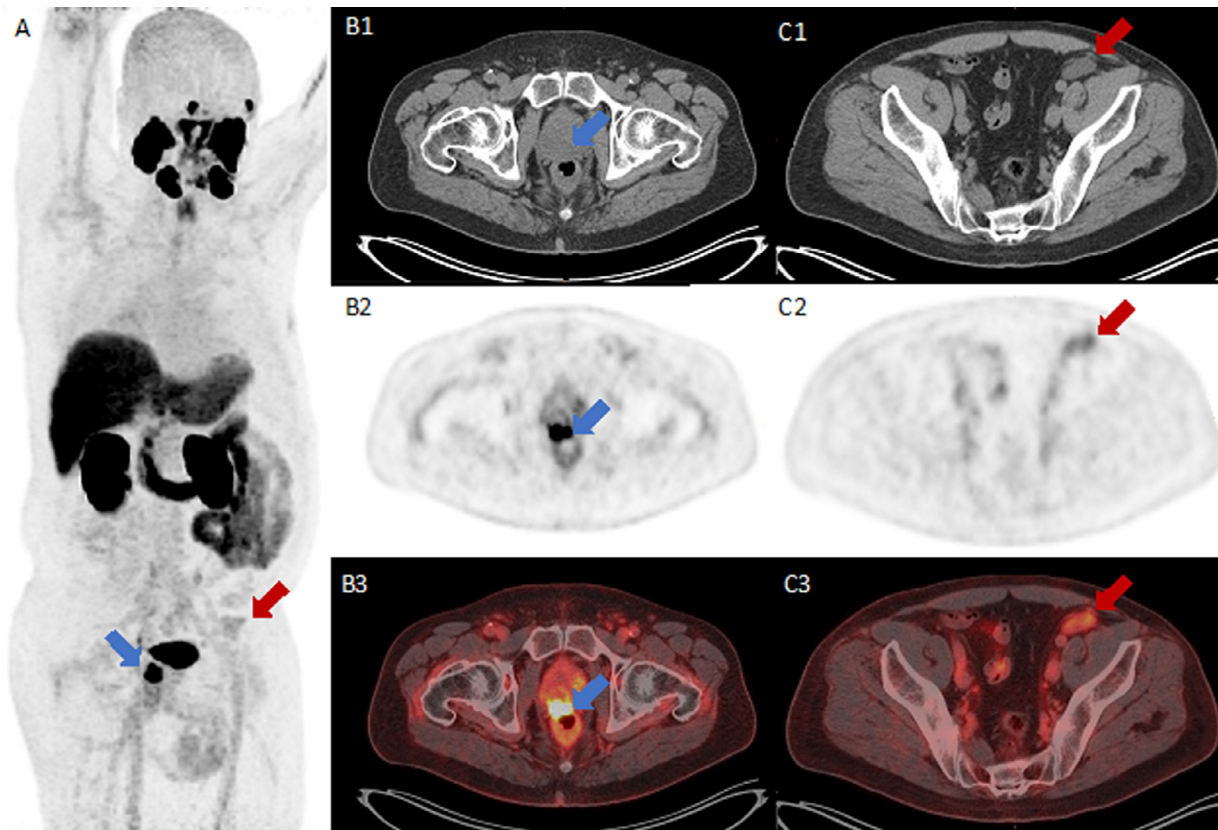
PSMA-PET/CT with findings significant for moderate tracer activity within the prostate gland (blue arrow, images A and B1-3) and mild tracer activity within a lobulated, hypoattenuating 3.5 x 1.5 cm structure along the distal left external iliac vasculature (red arrow, images A and C1-3).
